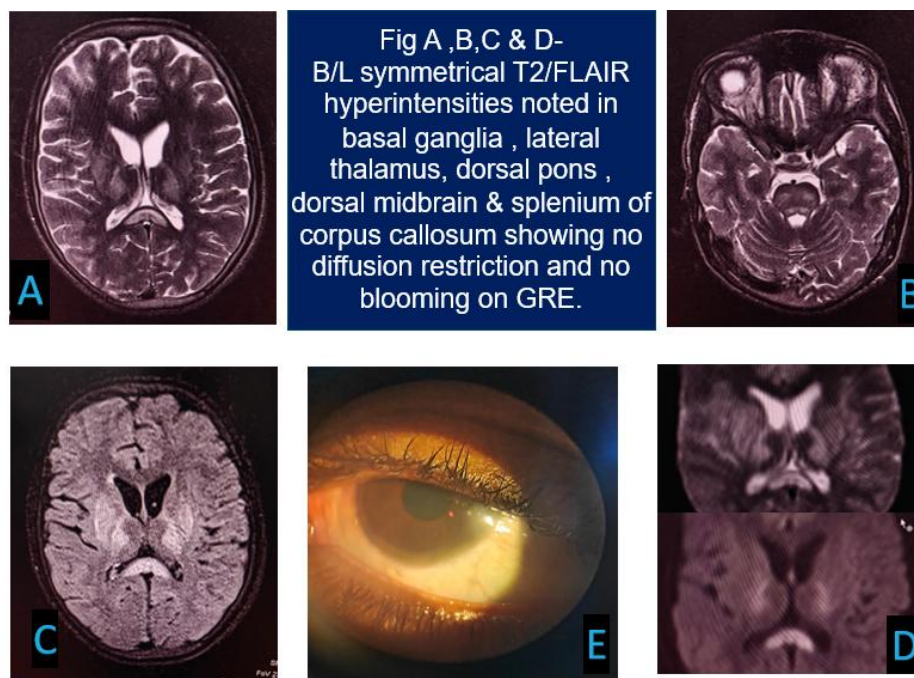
Axial T2/FLAIR MR images (A, B, D) show symmetric hyperintensity involving the basal ganglia, thalami, dorsal midbrain and dorsal pons; axial DWI (C) shows no diffusion restriction; slit-lamp photograph (E) demonstrates a Kayser–Fleischer ring at the corneal limbus.
